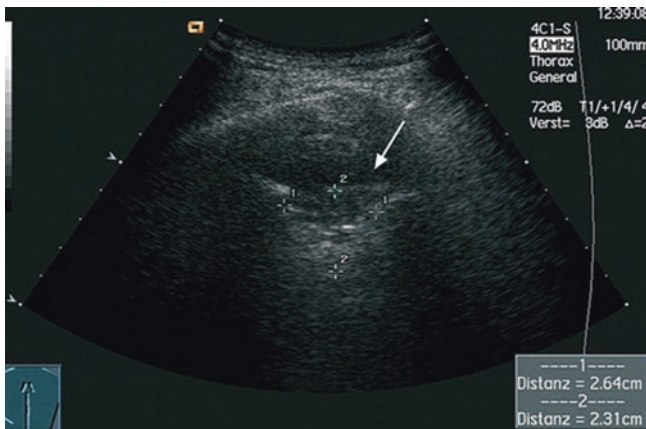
A 73-year-old man with a chronic cough, who was known to suffer from chronic obstructive pulmonary disease. Sonography showed an area with blurred margins in dorsal and basal location, with residual air. A small pleural effusion (arrow). *Mycobacterium tuberculosis* was cultured in the bronchial and pleural secretion
